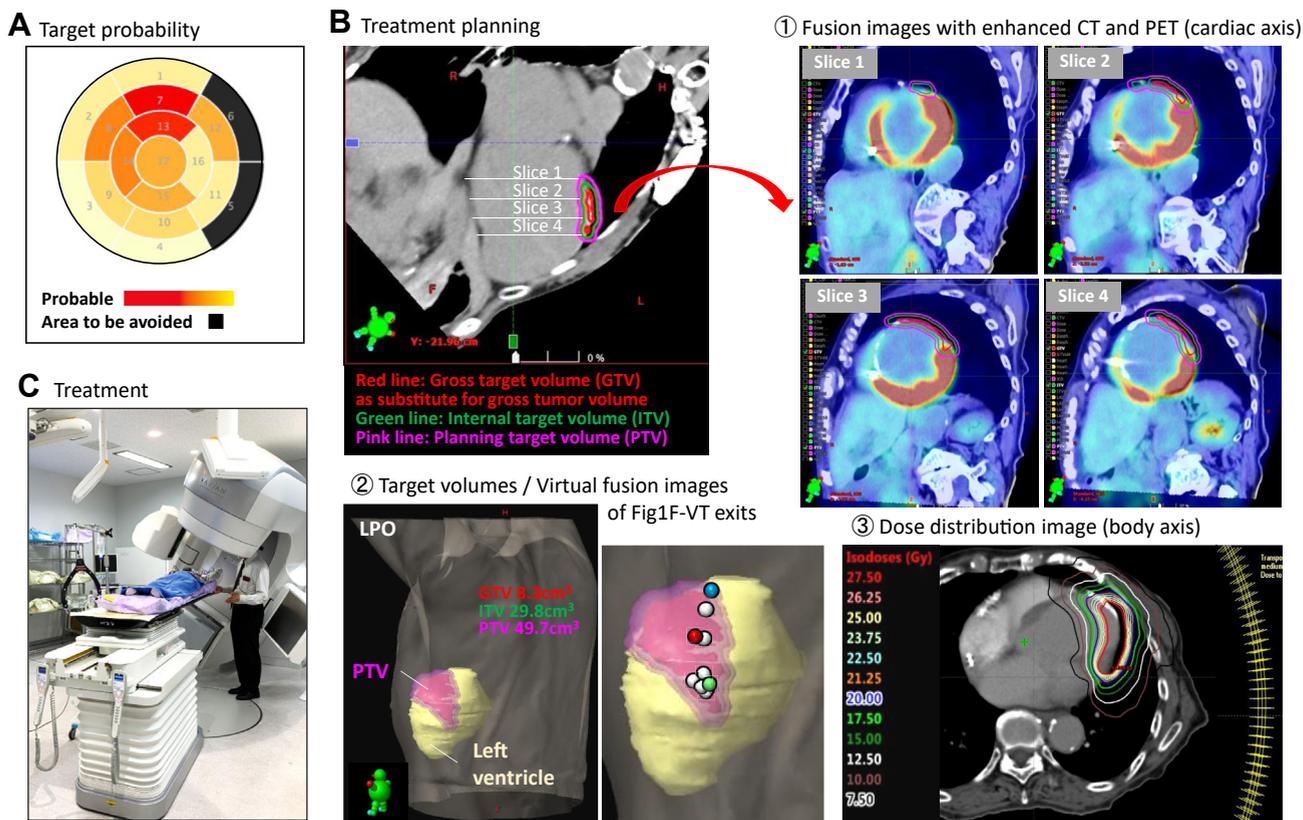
Radiation treatment plan. A: Target and non-target areas. B: Cardiac computed tomography (CT) with positron emission CT (PET) fusion images is used for contouring. C: Breathing instruction and treatment without anesthesia and pain-free conditions. LPO = left posterior oblique view.
